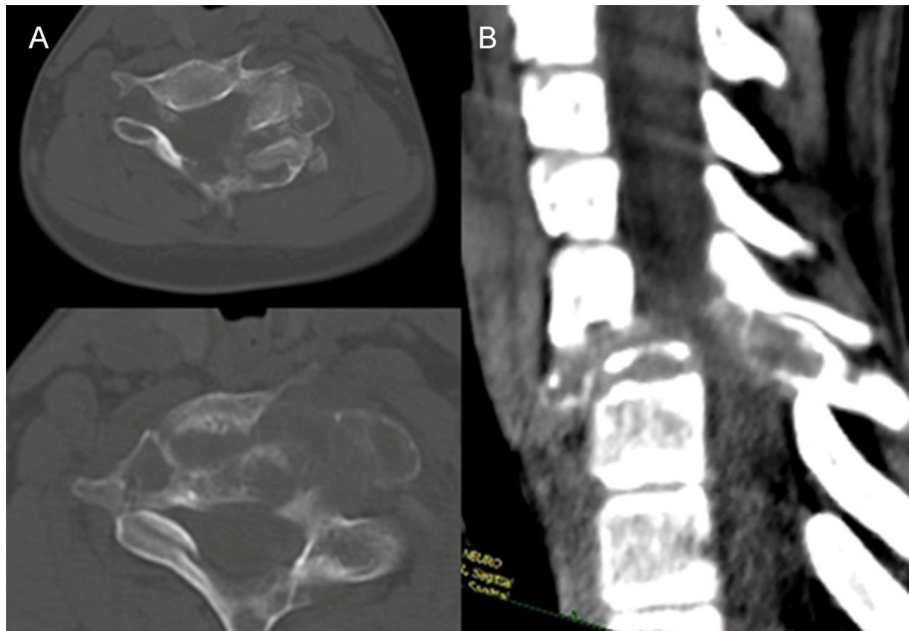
Radiological appearance of an ABC secondary to cervical osteoblastoma (CVII) A. axial CT images, B. sagittal CT reconstruction*
